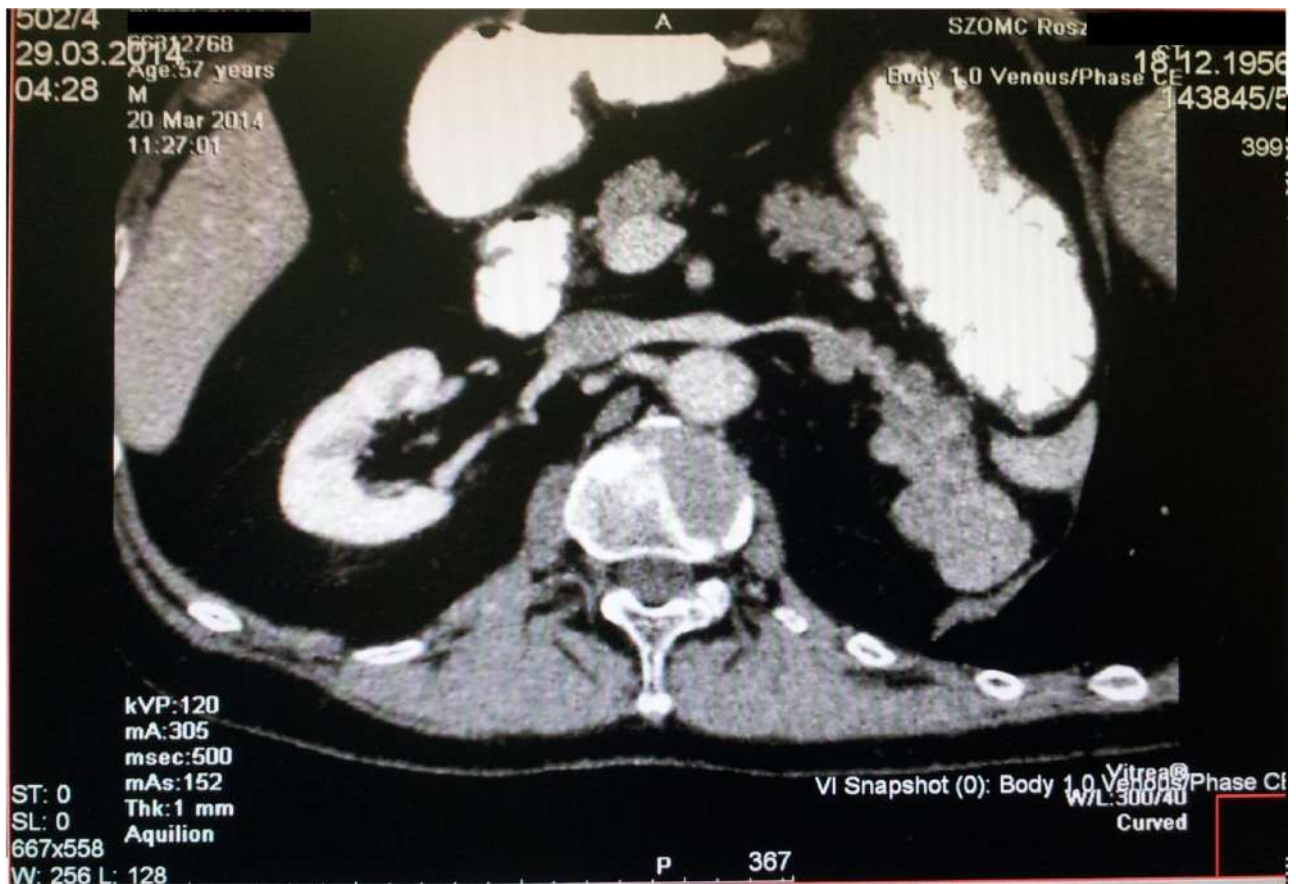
Adrenocortical carcinoma of the left adrenal gland. Computed tomography, venous phase of the study.
